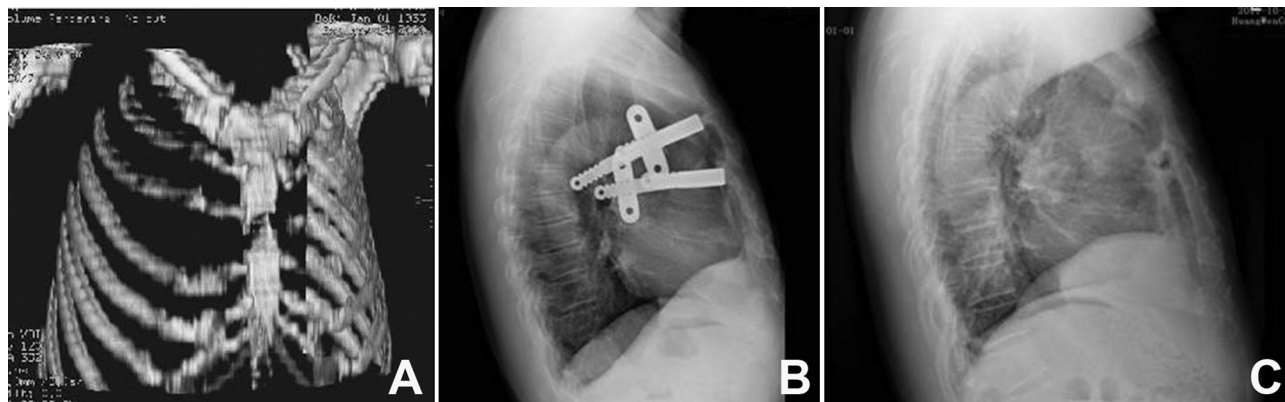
(A) Volume reconstruction (VR) presurgical three-dimensional computed tomographic scan. (B) Follow-up plain radiographs, 11 months after surgery. (C) Plain radiographs, 2 days after the bars were removed.
